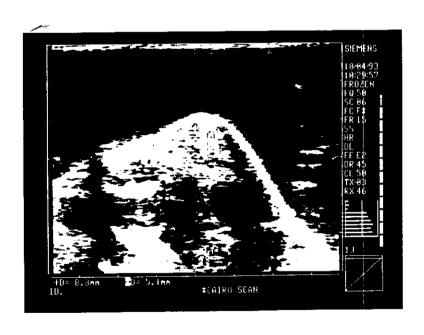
Sonography of tendo Achillis showing tendinitis
